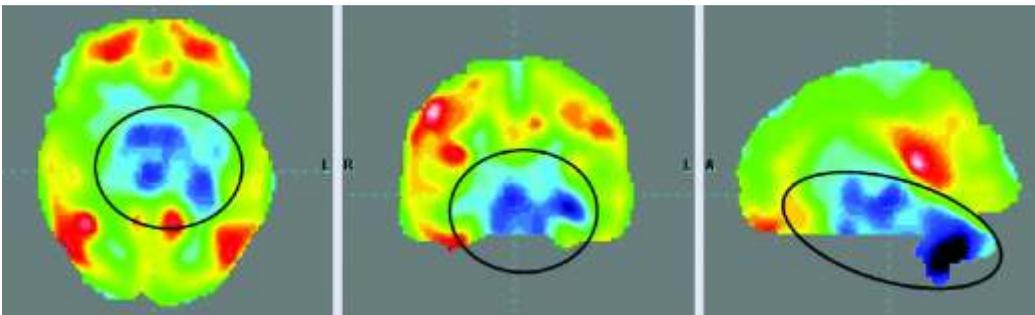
PET-CT scan before stem cell therapy showing reduction in the metabolic activity of the cerebellar lobes and thalami bilaterally
